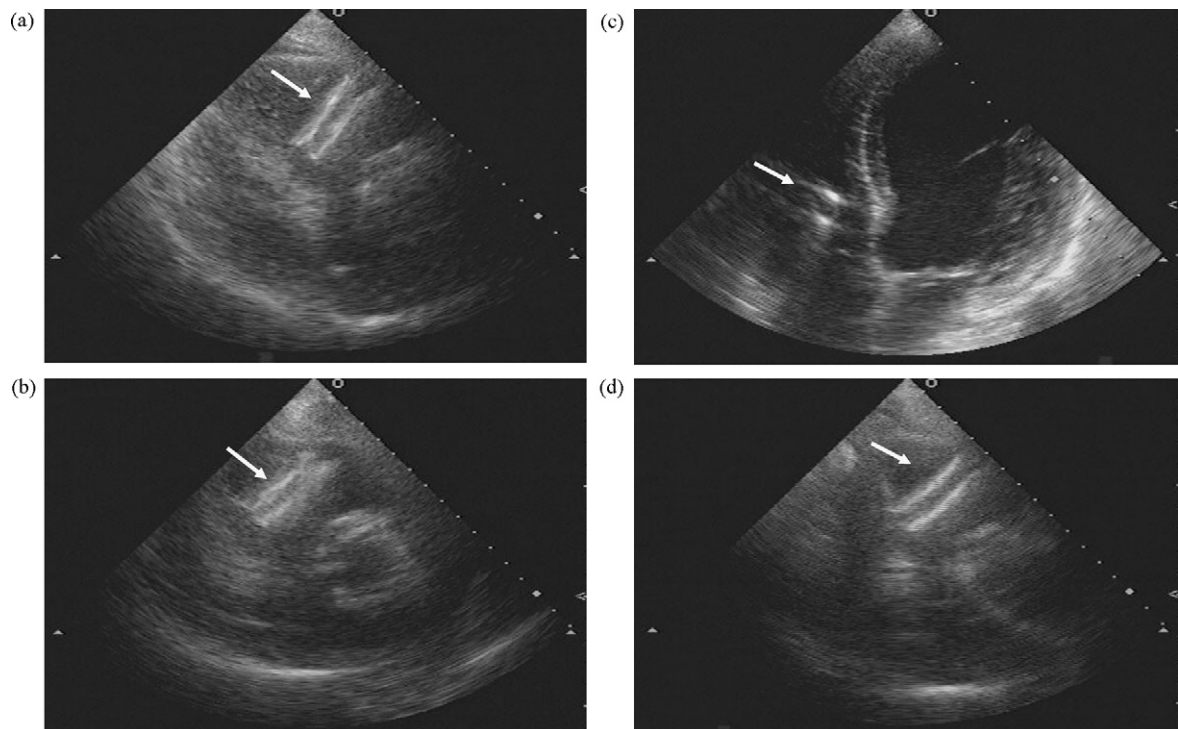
B-mode echocardiograms showing pipe-shaped structure with multiple slit and acoustic shadow (arrows) in right ventricle: (a) parasternal long-axis view; (b) parasternal short-axis view; (c) apical four-chamber view; (d) apical short-axis view.
